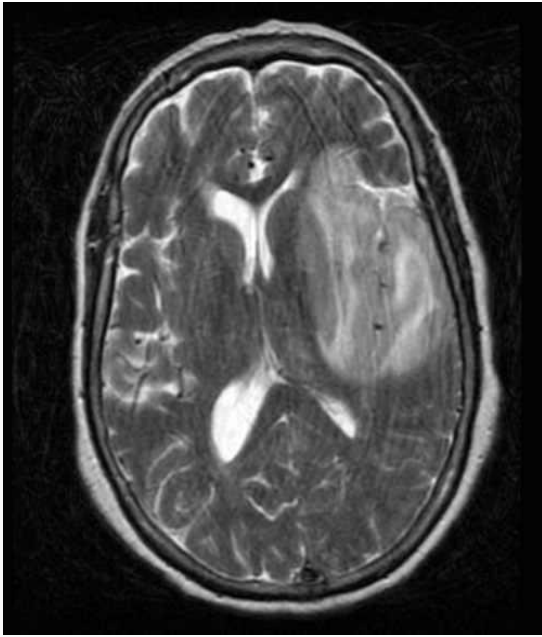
MRI of a patient with HSV encephalitis. There is hyperintensity of the affected white matter and cortex in the medial temporal lobes and insular cortex.
